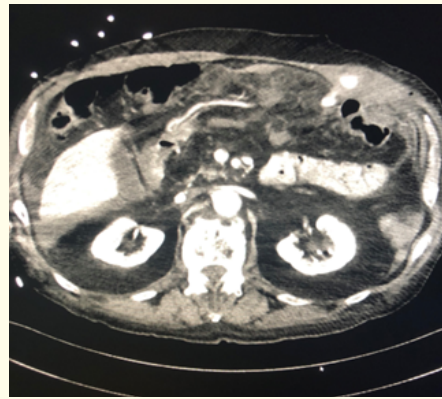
CT transverse axis, arterial phase. Bubble in subcutaneous left side, hematoma of the abdominal wall on the peritoneal profile.
